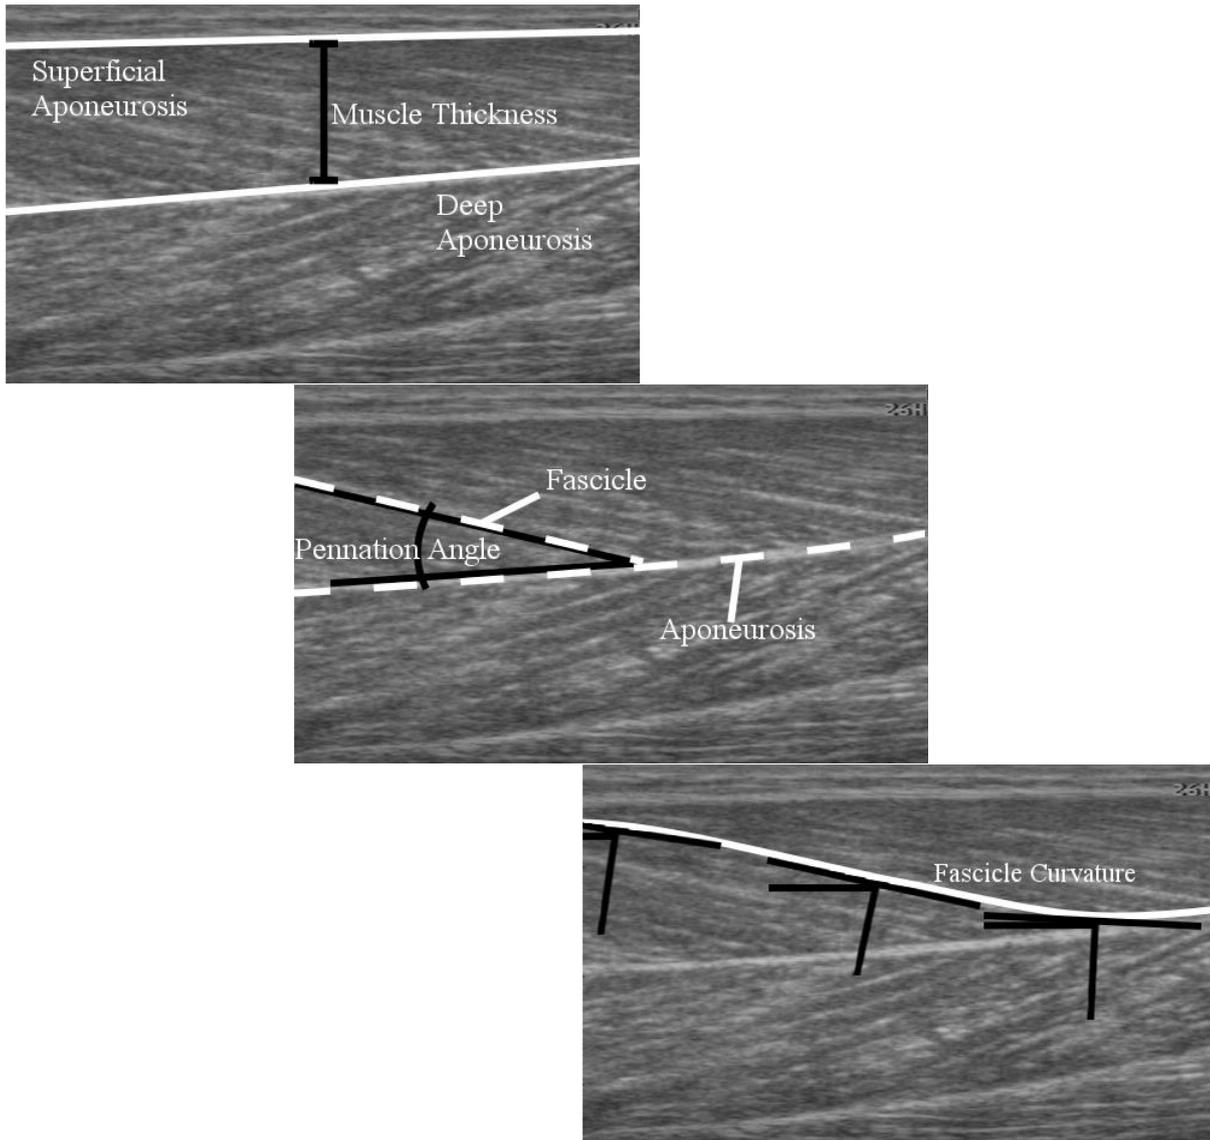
Skeletal muscle ultrasound primitive measurements. Top: muscle thickness is measured by taking the distance between superficial and deep aponeuroses. This measure is simple to calculate compared to taking the cross-sectional area, which is the area of the muscle region between superficial and deep aponeuroses. Middle: the pennation angle of fascicles as measured by computing the angle at which fascicles connect to the deep aponeurosis. Bottom: fascicle curvature is more difficult to measure as it involves computing the change in fascicle orientation between aponeuroses. All of these quantities change during contraction, and also during passive joint rotation.
